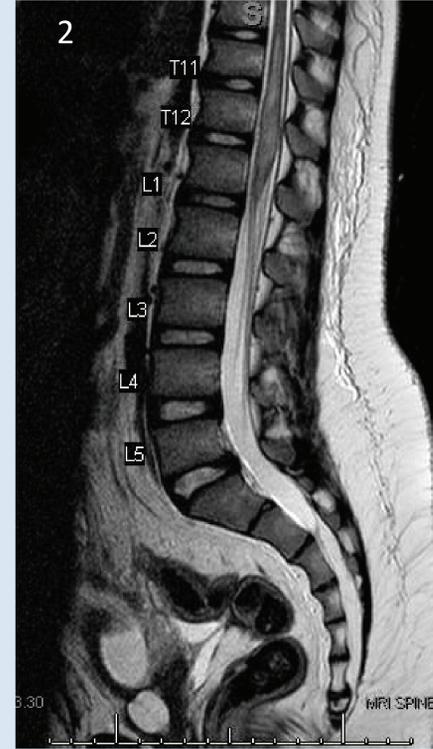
(above): T2-weighted sagittal MRI demonstrating hyperintense edema-like signal extending within the spinal cord from T10-T11 to the conus.
